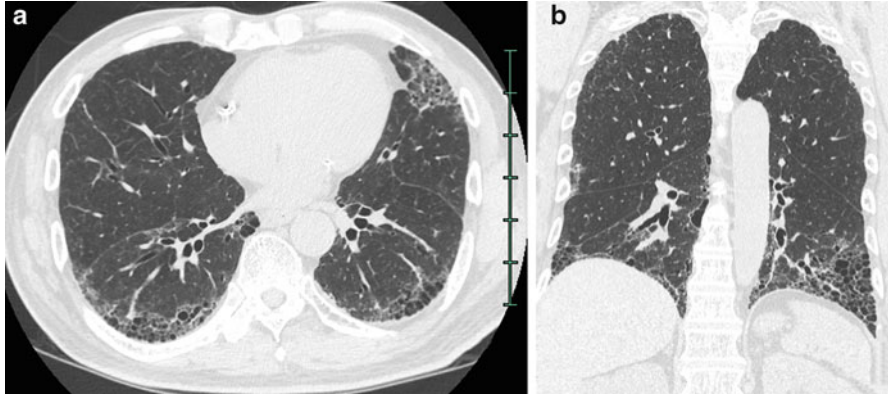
Typical honeycomb lung. (a) High-resolution computed tomography (HRCT) shows clustered multiple cysts of which walls are relatively thick. The diameter of each cyst is one cm or less. Honeycomb lung is located subpleurally. (b) Reformatted coronal image shows a constellation of multiple cysts located in the subpleural regions
